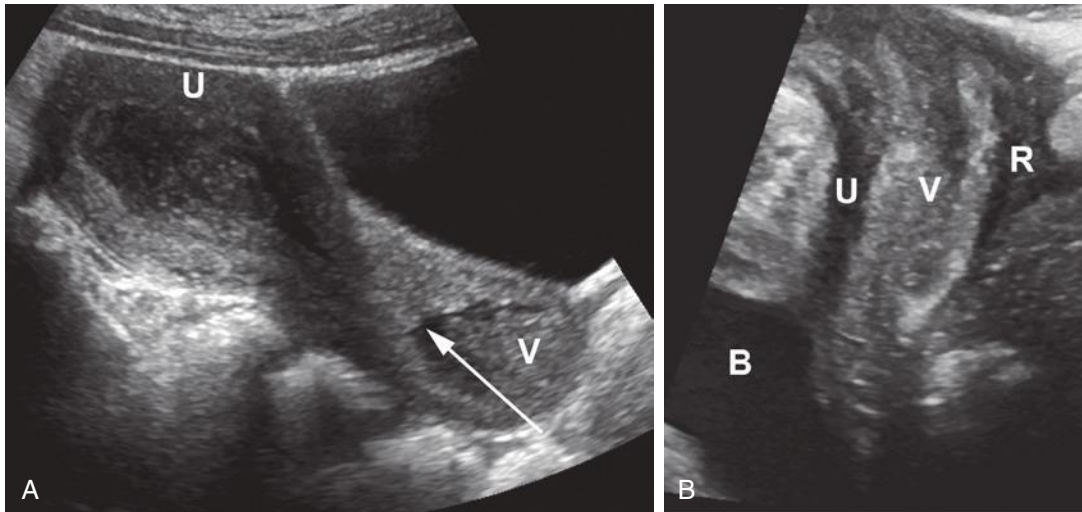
Transverse vaginal septum in a 12-year-old girl with normal external genitalia, primary amenorrhea, and pelvic pain. A, Sagittal ultrasound image depicts a fluid-distended uterus (U) and upper vagina (V). The arrow indicates the external cervical os. B, Sagittal transperineal image shows a collapsed distal vagina (V). B, bladder; R, rectum; U, urethra.
